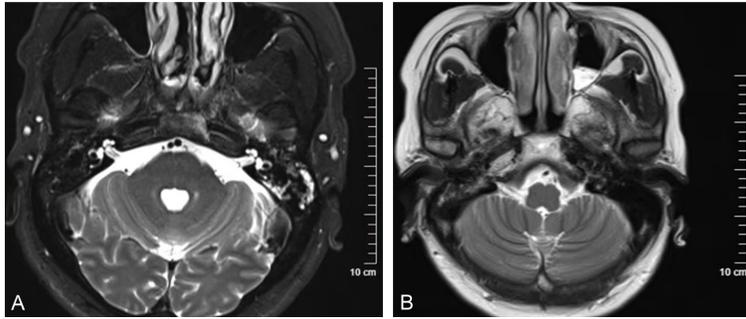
MRI images of the nasopharynx of nasopharyngeal carcinoma and normal individuals. A: MRI imaging of the nasopharynx in a normal subject; B: MRI imaging of the nasopharynx in a patient with nasopharyngeal carcinoma.
